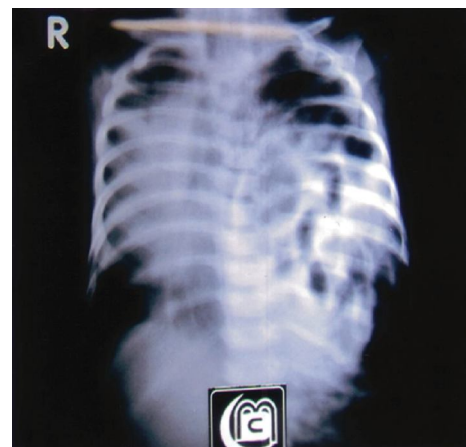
Plain X-ray of the abdomen and chest showing intrathoracic intestine and mediastinal shifting.
